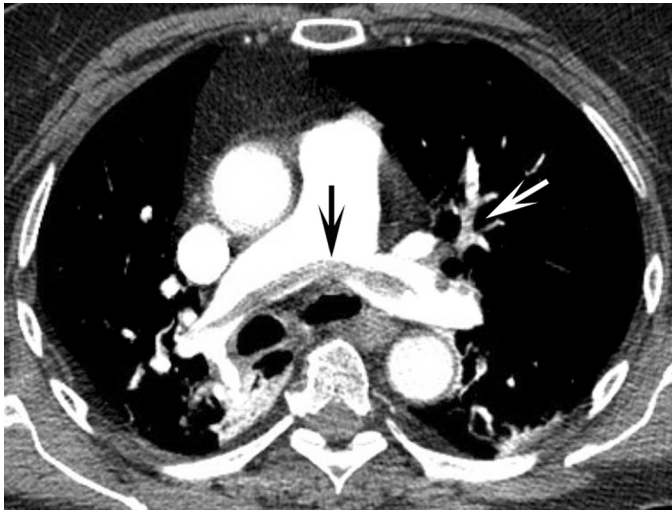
■ Axial computed tomography (CT) slice at the level of the hila. Saddle embolus (*black arrow*) in the distal main pulmonary artery, straddling the entire length of the right and left main pulmonary arteries. Occlusive pulmonary embolism also noted in a left upper lobe segmental branch (*white arrow*).
